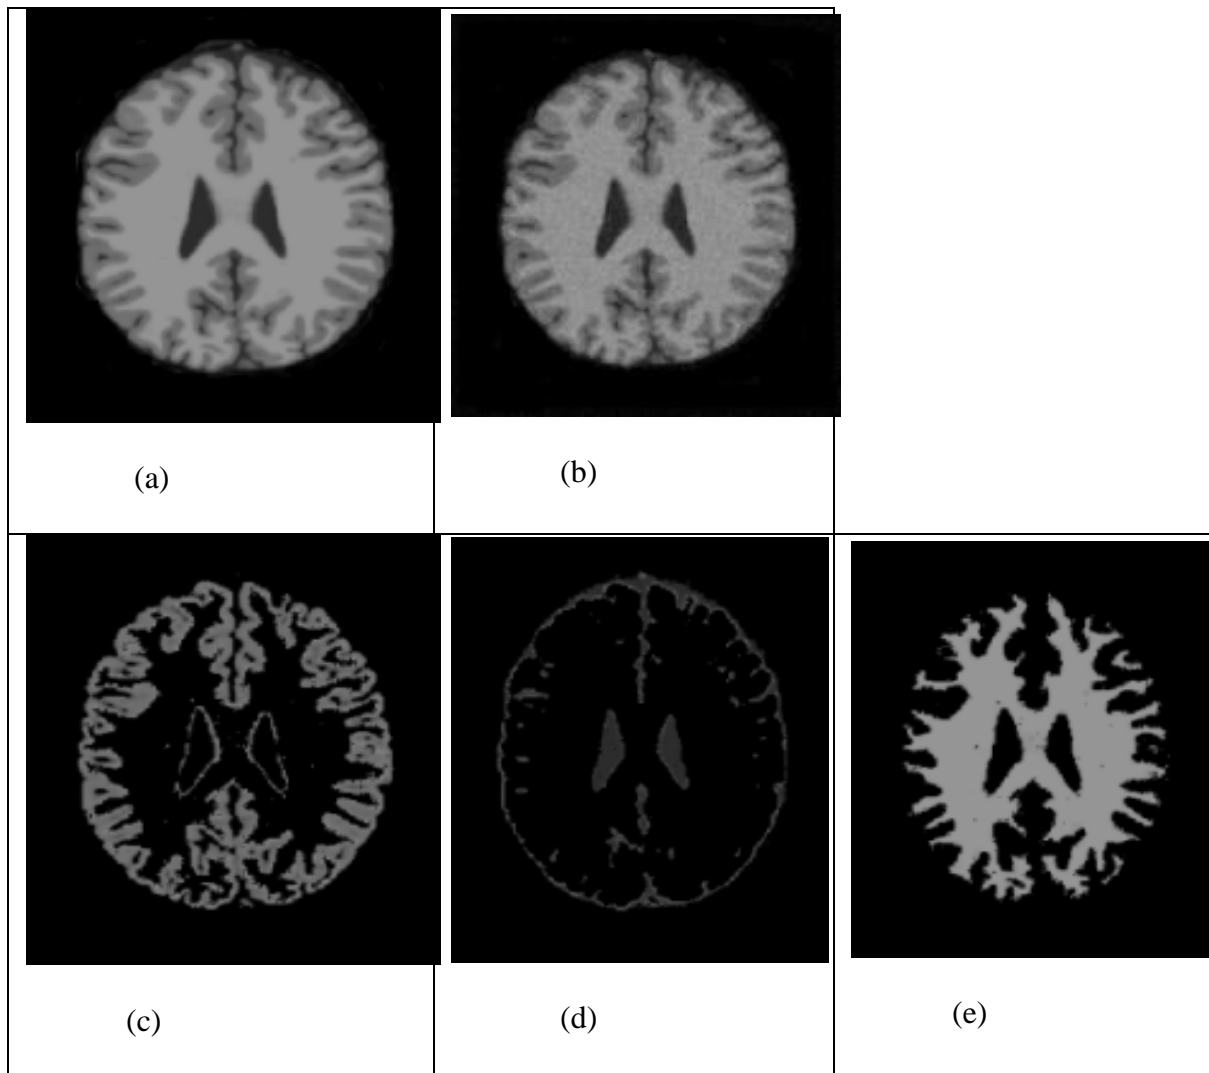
(a) Normal Brain(T1-weighted slice 99), (b) Normal brain (noise 5%), (c) Gray matter, (d) CSF, (e) White matter
